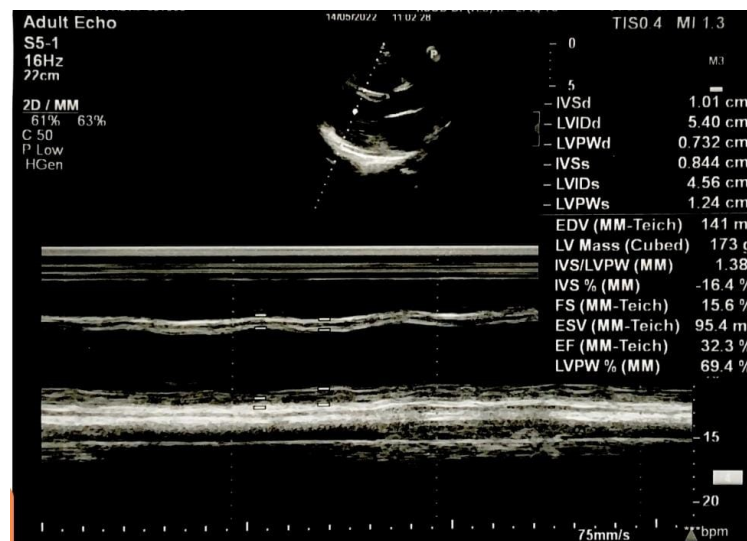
Echocardiography when the patient is in the first day of treatment
